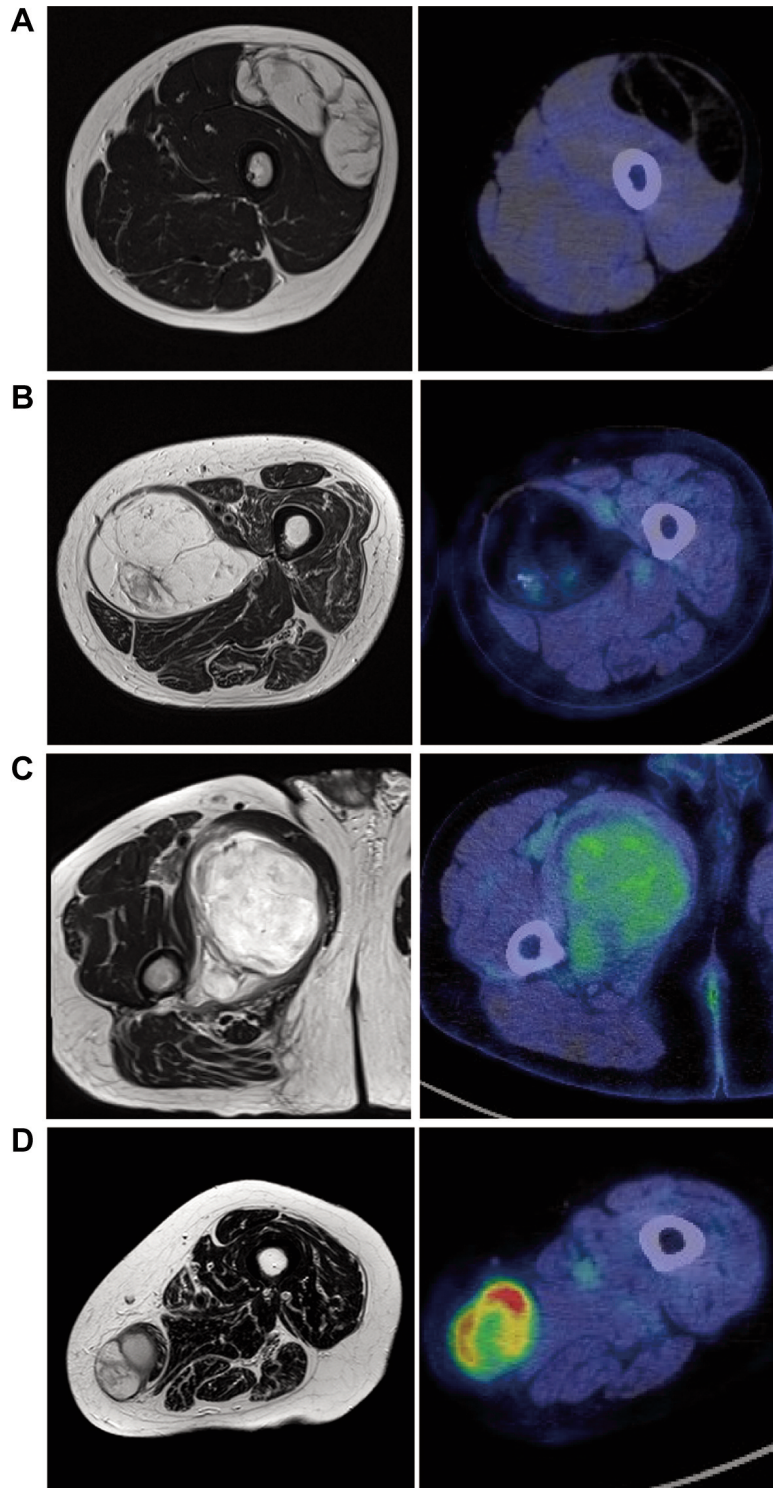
Representative images of magnetic resonance imaging (MRI) and ^{18}F -fluorodeoxyglucose positron emission tomography/computed tomography (^{18}F -FDG PET/CT) in lipomatous tumors. (A) 10-year-old boy with lipoma of the left thigh. Left, T2-weighted MRI. Right, PET/CT fused image. Maximum standard uptake value (SUV_{max}) of lipoma in the left thigh was 0.00. (B). A 72-year-old woman with an atypical lipomatous tumor (ALT) of the left thigh. Left, T2-weighted MRI. Right, PET/CT fused image. The SUV_{max} of ALT in the left thigh was 2.33. (C). A 48-year-old man with myxoid liposarcoma (ML) of the right thigh. Left, T2-weighted MRI. Right, PET/CT fused image. The SUV_{max} of ML in the right thigh was 3.63. (D). An 81-year-old woman with dedifferentiated liposarcoma (DL) of the right thigh. Left, T2-weighted MRI. Right, PET/CT fused image. The SUV_{max} of DL in the right thigh was 7.94.
